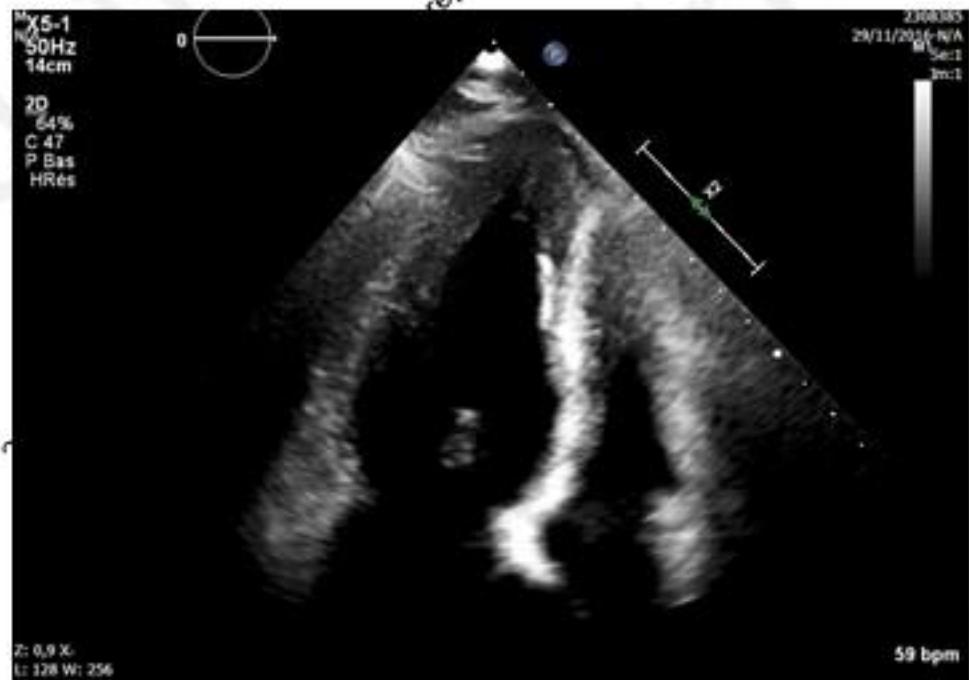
Two-dimensional echocardiography in four-chamber apical view and left ventricular endocardial biopsy from two patients (Patient #4 and Patient #18 of Table 2) with Fabry's disease cardiomyopathy (A,D and B,E, respectively) and a patient with hypertrophic cardiomyopathy (C,F). Comparison of the three echocardiographic frames reveals the presence of a binary appearance of left ventricular endocardial border in the two Fabry patients (A,B). This echocardiographic finding reflects the glycosphingolipids compartmentalization involving a thickened endocardium (End) with enlarged and engulfed smooth muscle cells (SMC), a subendocardial empty space (SES), and a prominent involvement of subendocardial myocardial layer (SL), while the middle layer (ML) appears partially spared (D,E). The echocardiographic pattern is absent in hypertrophic cardiomyopathy (C), despite a similar thickening of the endocardium (F).
